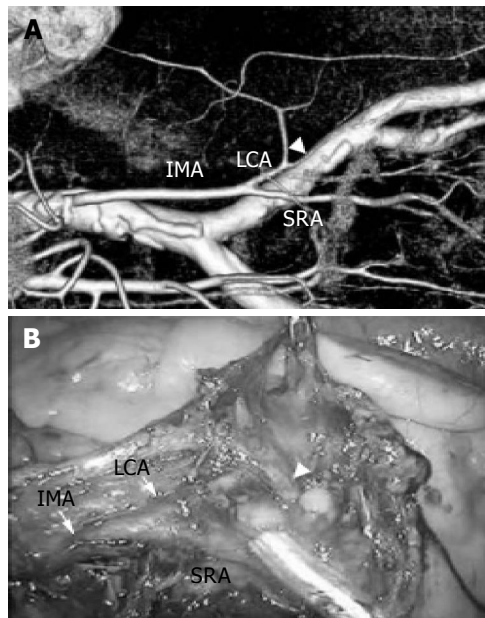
A case of sigmoid colon cancer who underwent a laparoscopic sigmoidectomy. A: Three-dimensional volume-rendered CT (3DCT) angiographic reconstructions show the IMA and its branches; B: The intraoperative findings similar to the preoperative visualization of the IMA were obtained. White arrowheads show the sigmoidal artery.
